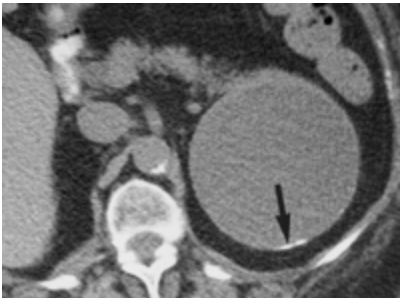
Incidental mass found on lumbar spine MRI of an 80-year-old woman with low back pain. A large, unilocular mass in the pancreatic tail can be seen on this CT scan. Note calcification in the wall at the site of the arrow. (American Journal of Radiology 2001; 176: 921-929)
